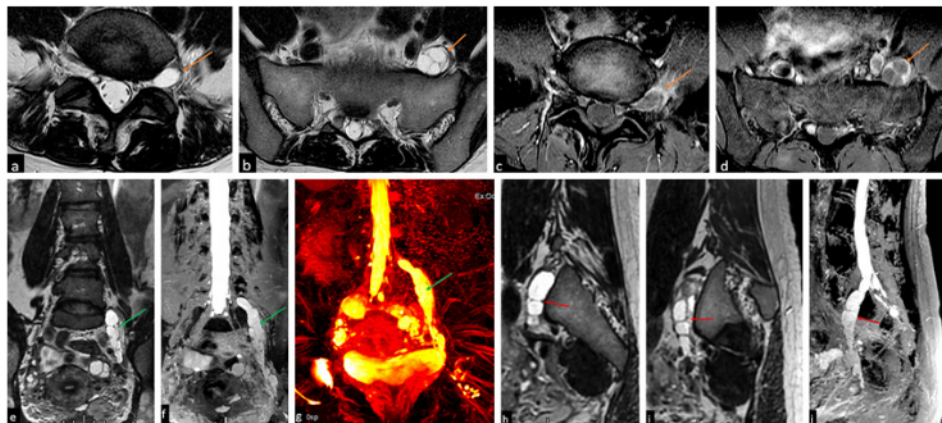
Contrast-enhanced lumbosacral MRI. 3-T MRI was performed in axial T2FRFSE, sagittal T1FSE, T2FRFSE, and T2 Fat Sat, and MR neurography with 3D STIR. a, b Axial T2-weighted sequence demonstrating a cystic mass (orange arrows) in foraminal zone L5–S1 along the passage of the ischial nerve to the left ischial sulcus at the level of the left lateral presacral space. c, d Enhanced T1-weighted sequence demonstrating peripheral rim contrast enhancement (orange arrows) consistent with an encapsulated cystic mass. e–j Coronal T2-weighted sequence (e, f) and 3D STIR MR neurography (g) (green arrows), as well as sagittal T2-weighted sequence (h, i) and MR neurography (j) showing a long mass in the sciatic nerve in the foraminal zone and the left sulcus (red arrows) with a lesion length of ± 13.90 cm and a maximal diameter of ± 1.91 cm.
